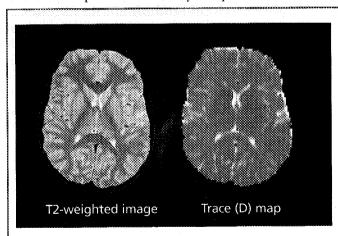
Axial T2-weighted image of healthy volunteer (left), and the corresponding Trace(D) map (right). White and gray matter have similar values of Trace(D).
